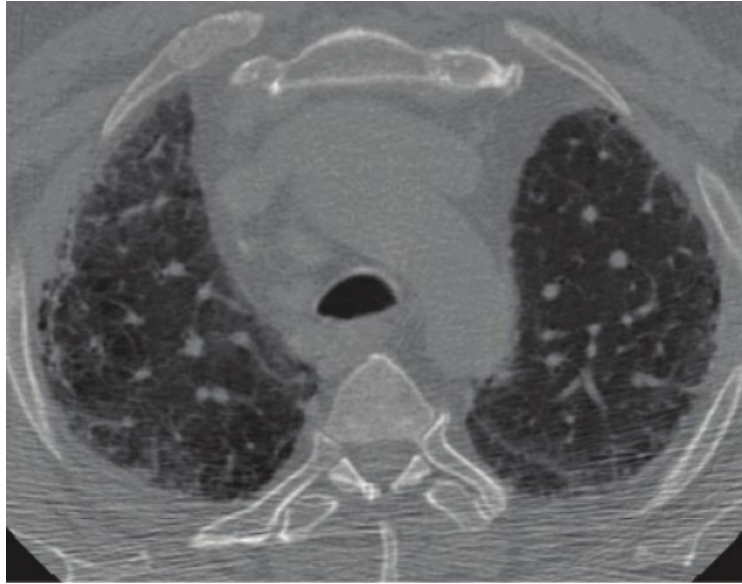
CT scan showing the lung of a patient from our PH pilot study with idiopathic pulmonary fibrosis (IPF).
